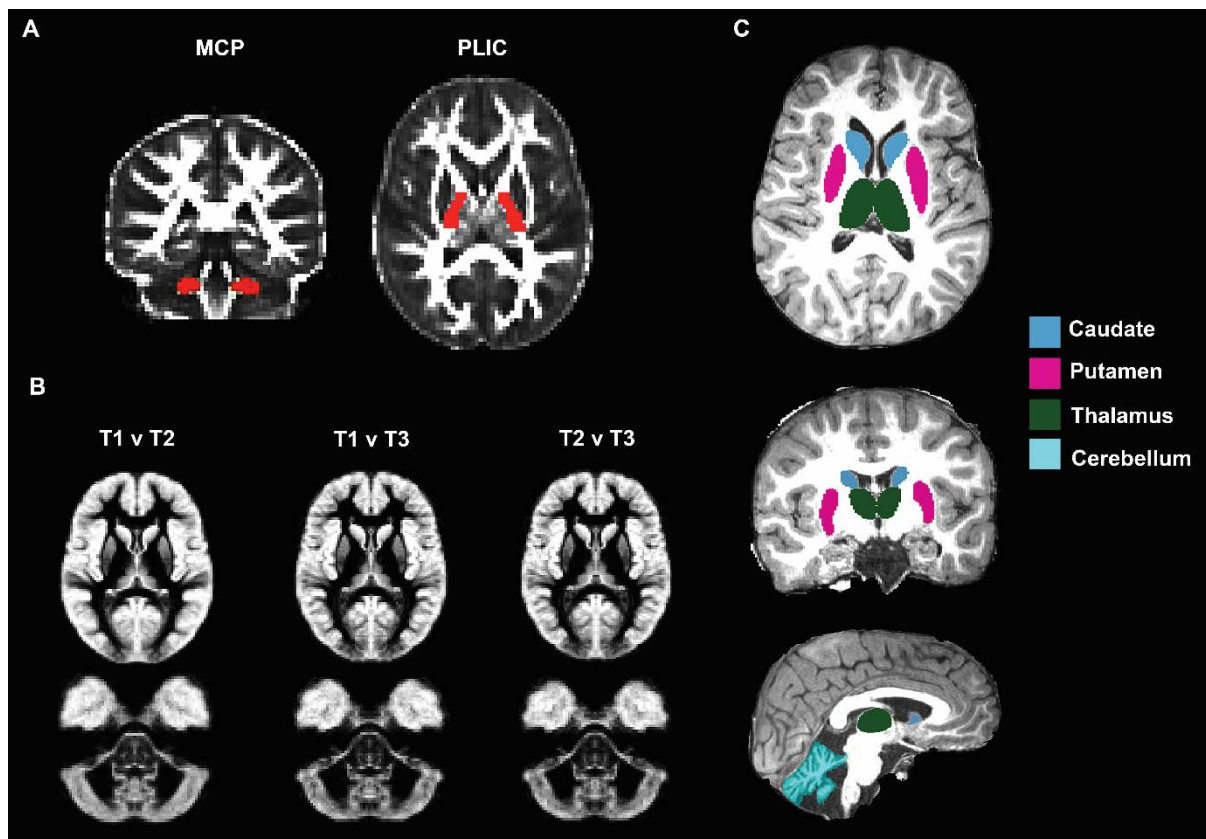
A) Regions of interest (ROIs: depicted in red) of the left and right medial cerebellar peduncle (MCP) and posterior limb of the internal capsule (PLIC) are overlaid on the ataxia-telangiectasia (A-T) patient fractional anisotropy (FA) template. B) Grey matter (GM) template of patient data set comparisons (time points 1 versus 2 (T1 v T2), time points 1 versus 3 (T1 v T3) and time points 2 versus 3 (T2 v T3), respectively) in the mid-cerebral (z -axis=39) and mid-cerebellar (z -axis=15) plane. C) Structural T1-weighted images in the axial (first row), coronal (second row) and sagittal (third row) planes of an 8-year-old A-T patient brain with automated segmentation of the caudate, putamen, thalamus and cerebellum in cerebral and cerebellar hemispheres are presented.
